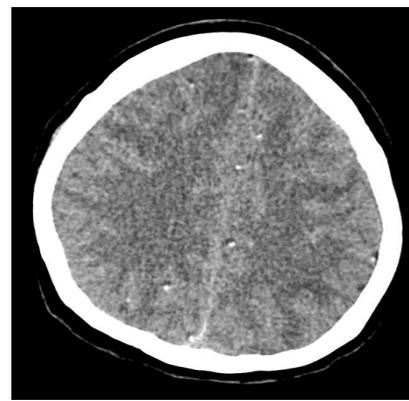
CT axial section at high parietal region.
